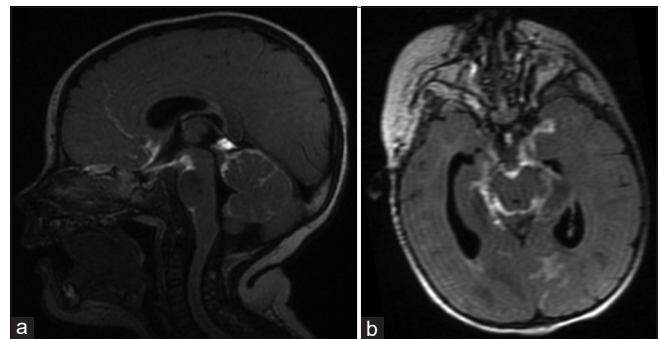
Eleven months old with fever and progressive neurological symptoms. Midline sagittal cube FLAIR post-contrast image of the brain (a) from the initial MRI demonstrates marked meningeal enhancement of the inferior frontal lobes, brainstem, and cerebellum with a thick enhancement of the basal cisterns. Axial post-contrast T1-FLAIR image (b) at the level of the basal cisterns shows characteristic encasement by thick enhancing exudates lining these cisterns.
